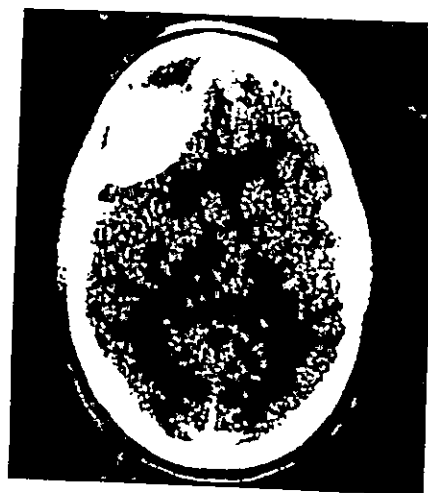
CT scan of intracranial injury. Axial CT section obtained in victim of closed-head injury demonstrates large epidural hematoma occupying right frontal area. A significant associated mass effect is seen with compression of frontal horns of ventricles. Convex margin toward brain and sharply defined edges is typical of epidural hematoma.
